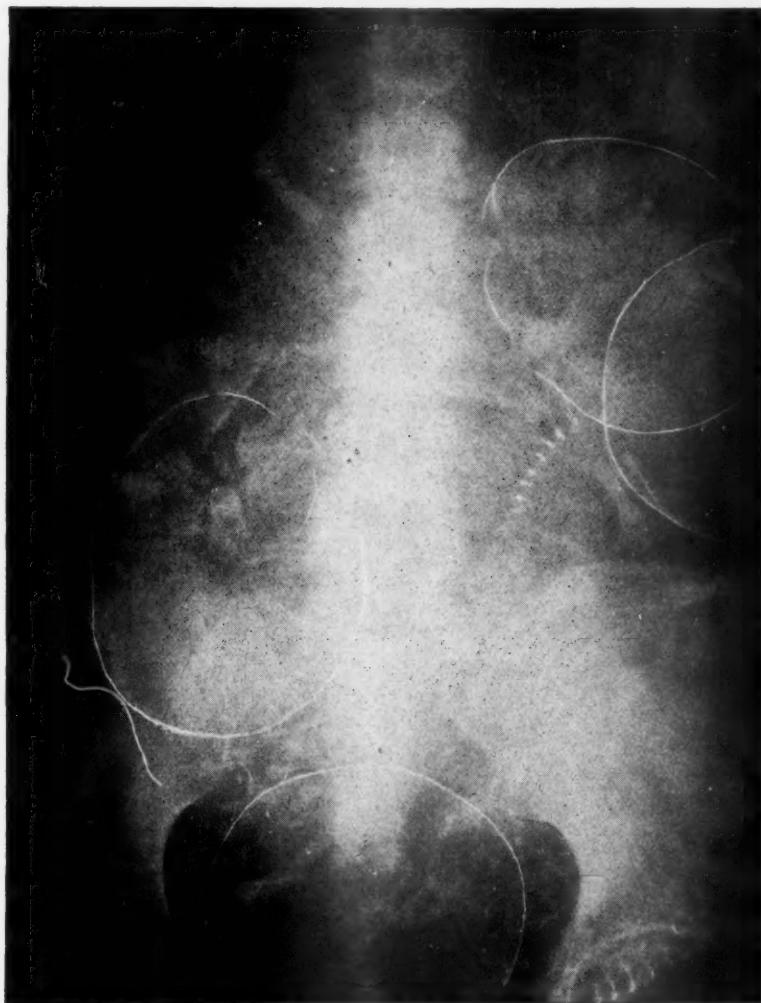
X-ray taken at seven and one-half months (retouched).
